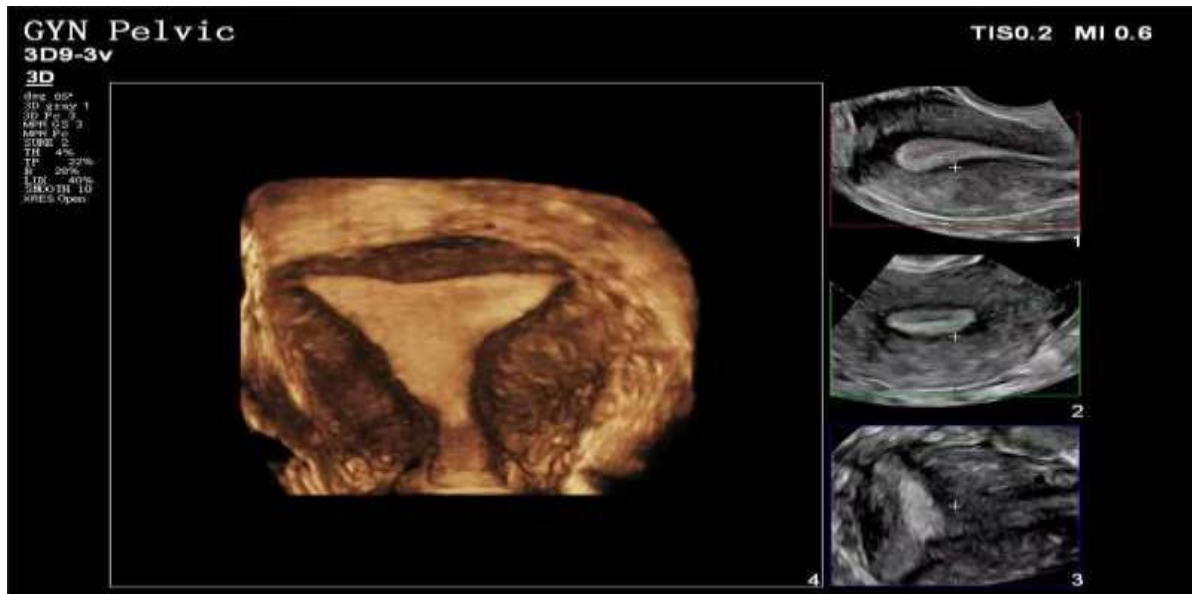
Transvaginal three-dimensional ultrasonography provides a thorough endometrial imaging.
